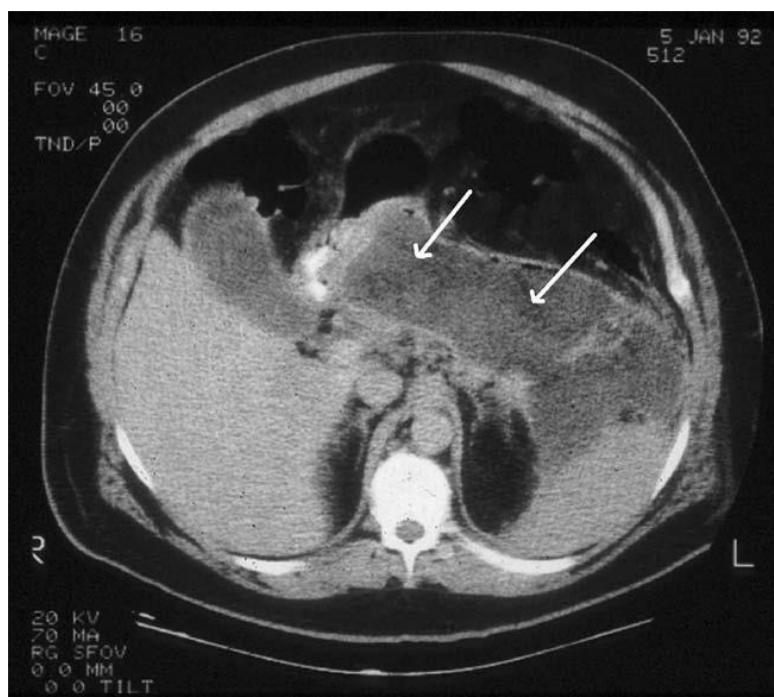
A CT scan demonstrating a large area of necrosis as evidenced by the lack of contrast enhancement after intravenous contrast administration
